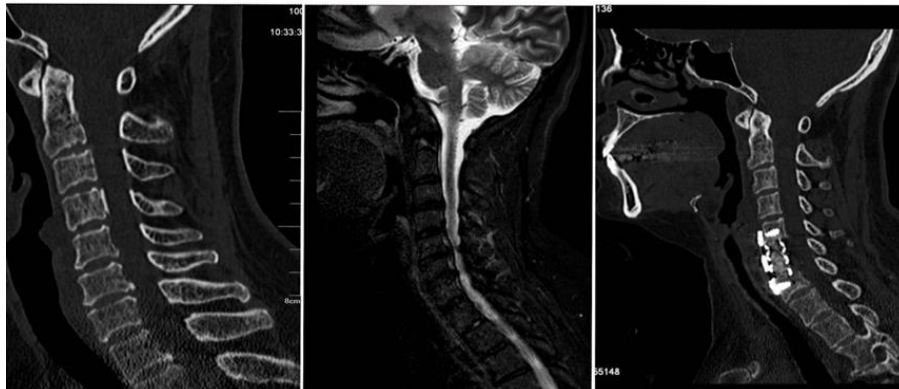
Shows example of anterior approach, images from left to right, 1: preoperative CT scan, 2: preoperative MRI, 3: post-operative CT.
